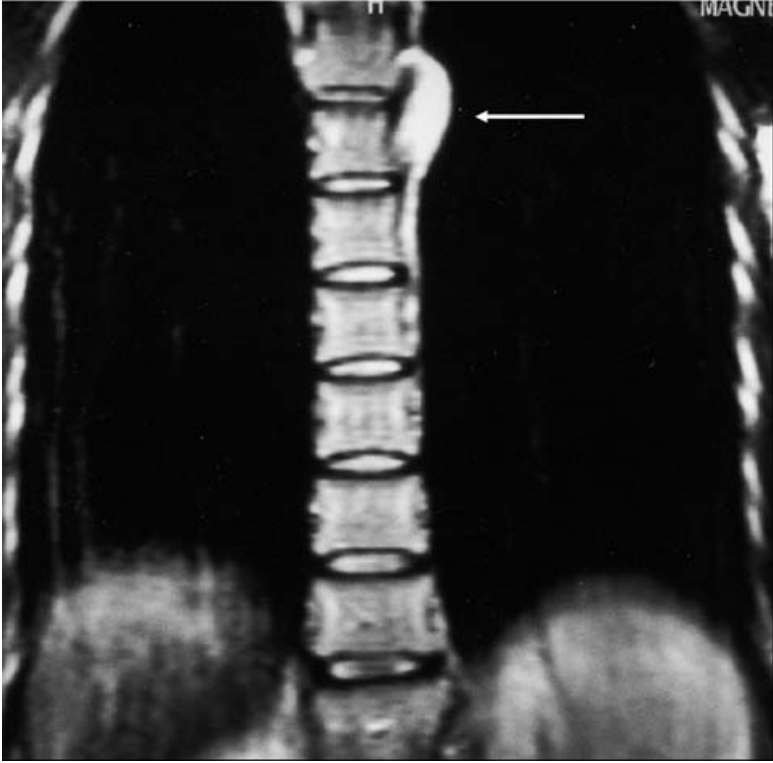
Paraganglioma syndrome in a 23-year-old women. This patient showed a mutation in the *SDHD* gene. (A) Right adrenal pheochromocytoma in CT (arrow), (B) and (C) thoracic paraganglioma (arrow) in CT (B) and MRI (C) and, (D) paraganglioma of the right glomus jugulare (arrow).
